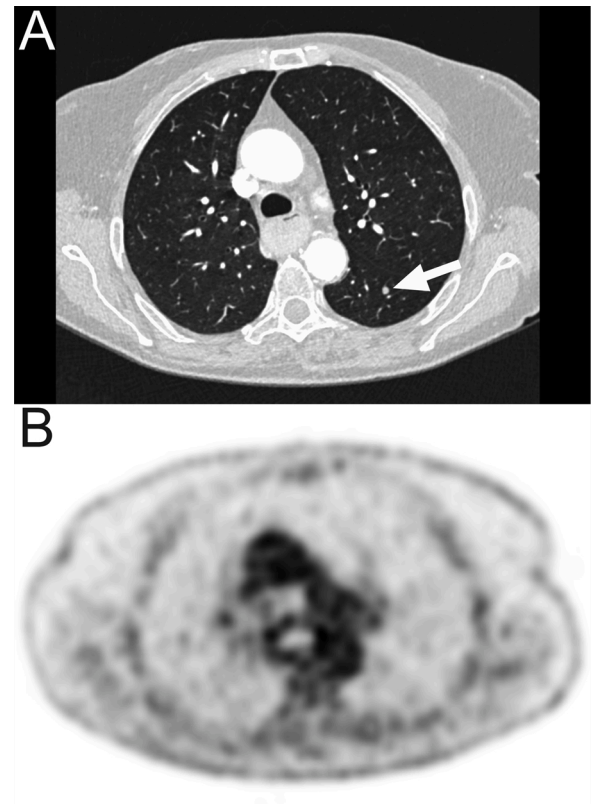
A 77-year-old woman with a history of colon cancer, oropharyngeal cancer, and recently diagnosed esophageal cancer. Low-dose FDG-PET/CT and concomitant full-dose contrast-enhanced CT were performed for staging purposes. FDG-PET/CT showed pathologic FDG uptake in the esophageal cancer and several FDG-avid locoregional lymph nodes (not shown). Axial CT in lung window settings (A) and FDG-PET (B) are demonstrated. CT shows a 5-mm pulmonary nodule (A, arrow) without any visible FDG uptake at PET (B). This nodule was considered suspicious for metastatic disease in the original report. However, this nodule was also present at CT performed 2 years before. Therefore, it was highly unlikely to represent a lung metastasis. This cognitive error was corrected with an addendum one day after authorization of the original report.
